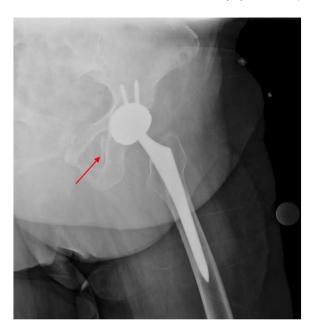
Lateral radiograph of the pelvis revealing a bony fragment arising from the left ischium.
